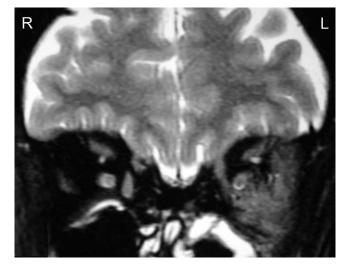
T2-weighted coronal MRI of a patient with Wegener's granulomatosis showing a mass involving the left maxillary sinus and extending into the left orbit.
